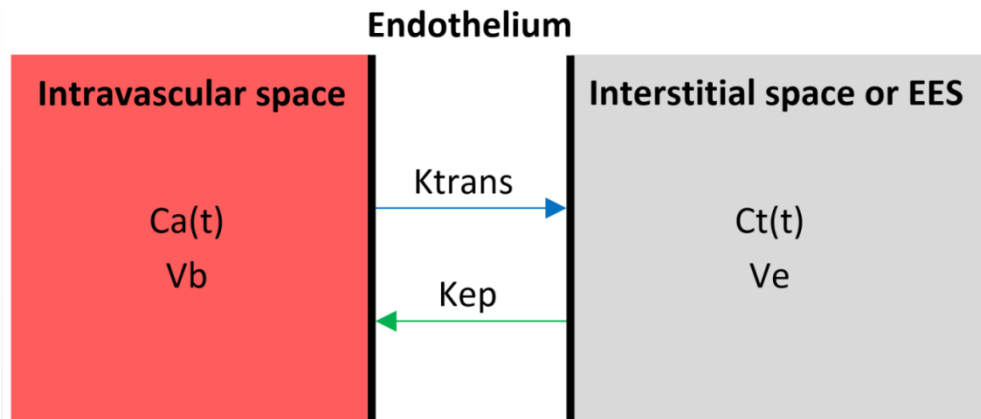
The assumptions used by dynamic contrast-enhanced magnetic resonance imaging (DCE-MRI) are based on the two compartment model of Tofts. Two compartments are assumed in this model: the intravascular space and the extracellular extravascular space (EES or interstitial space). The model provides information about the distribution of contrast agent across these compartments. C_a : arterial contrast agent concentration in function of time; C_t : tissue contrast agent concentration in function of time; V_b : whole blood volume per unit of tissue; V_e : total EES volume; K^{trans} : transfer constant; K_{ep} : reflux constant.
